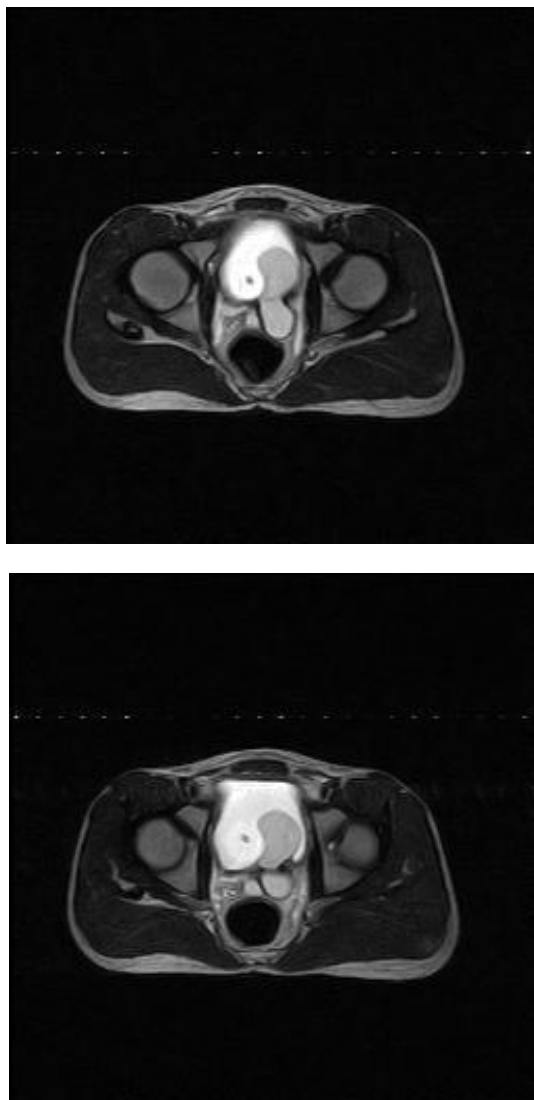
MRI imaging of left seminal vesical cyst obstructing the bladder neck
